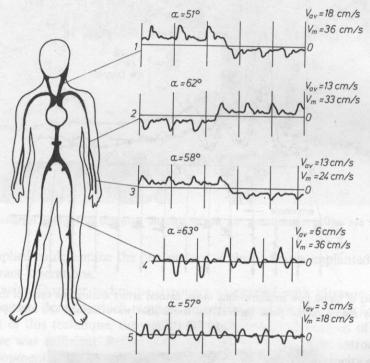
Quantitative blood velocity examinations by means of an automatic Doppler system eliminating the angle dependence between the ultrasonic beam and blond direction [17, 45] (1978).
